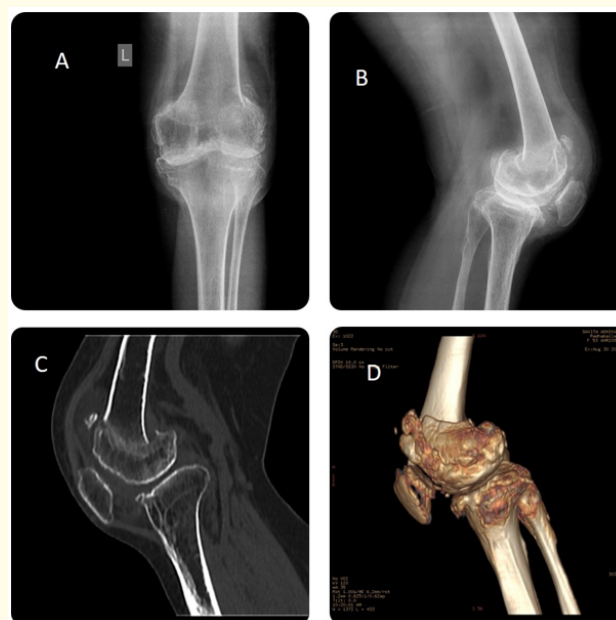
Pre-operative radiological investigations showing distal femur fracture with arthritic knee (a): Anteroposterior (AP) X-ray radiograph Left knee (b) Lateral X-ray radiograph Left knee (c) AP Left knee CT with 3D reformat (d) Lateral Left knee CT with 3D reformat.
